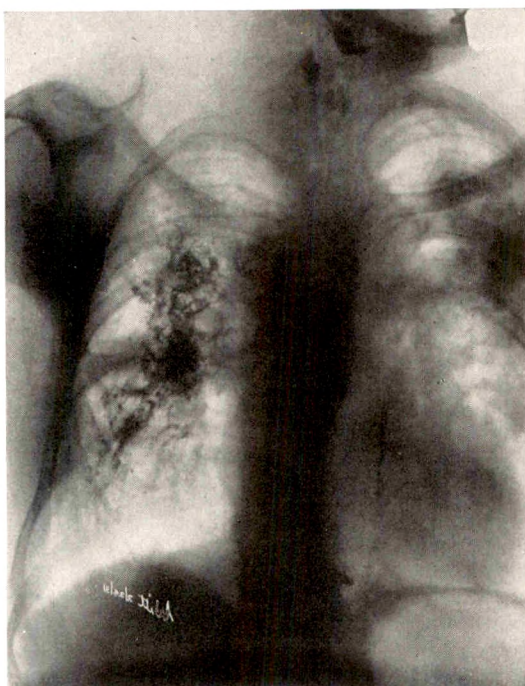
Case J.W. (Dec. 24, 1931). Roentgenogram made after the patient had collapsed and died following the instillation of lipiodol.
